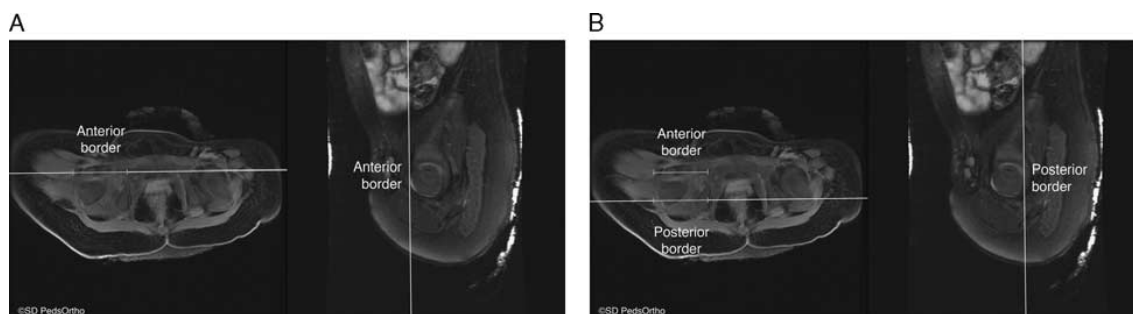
Axial (left image) and sagittal (right image) in sync magnetic resonance images demonstrating how the anterior border of the joint is identified (A), followed by the posterior border of the joint (B).
